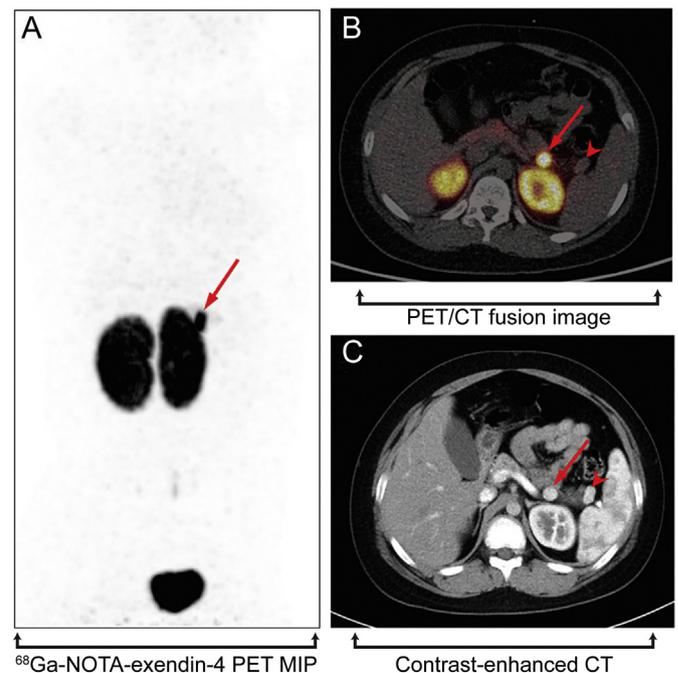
Value of ^{68}Ga -NOTA-exendin-4 in the preoperative localization of insulinoma. Maximum-intensity-projection PET image (A) and axial PET/CT fusion image (B) obtained from a 10-y-old boy 1 h after injection of 48.1 MBq of ^{68}Ga -NOTA-exendin-4. Red arrow showed intense uptake in the body of the pancreas (SUV_{max} , 27.1) and a mass near the spleen without obvious radiotracer concentration. (C) Arterial-phase contrast-enhanced CT image from same patient further showed an enhanced insulinoma (red arrow) and intrapancreatic accessory spleen (red arrowhead), both of which were subsequently confirmed by pathological examination. Adapted with permission from [28].
